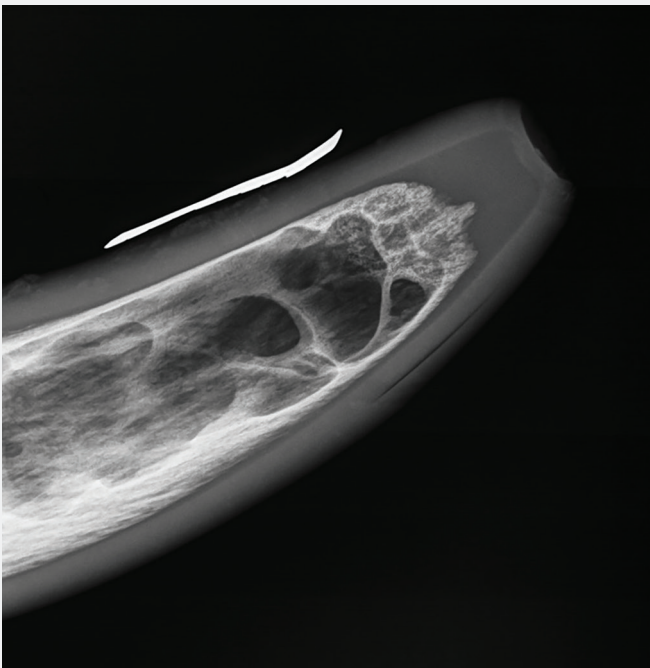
Radiographs can be taken with a metal marker placed on the horn and a cut can then be safely made distal to the sinus to avoid complications and promote faster healing.
